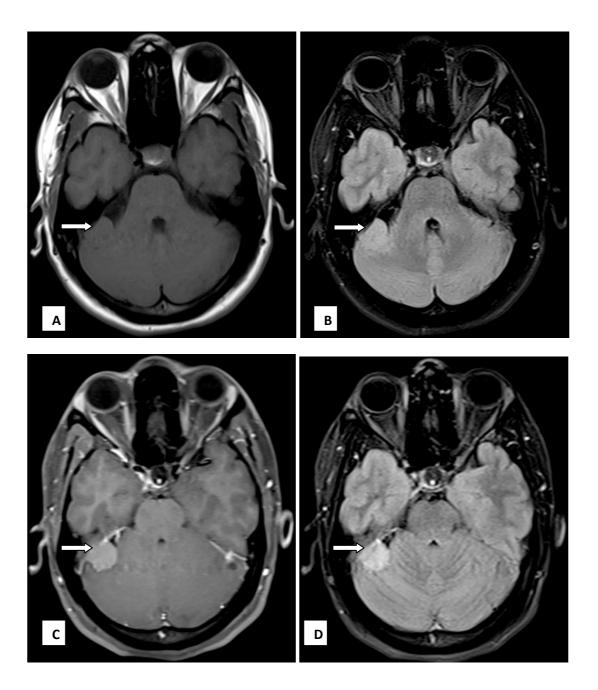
MRI Brain axial sections of 29 year old female diagnosed with right cerebellopontine angle meningioma showing a well-defined, T1 isointense (A) & (B) T2 FLAIR heterogeneously hyperintense lesion demonstrating mild enhancement on (C) T1 FS PC & moderate enhancement on (D) T2 FLAIR PC images.
